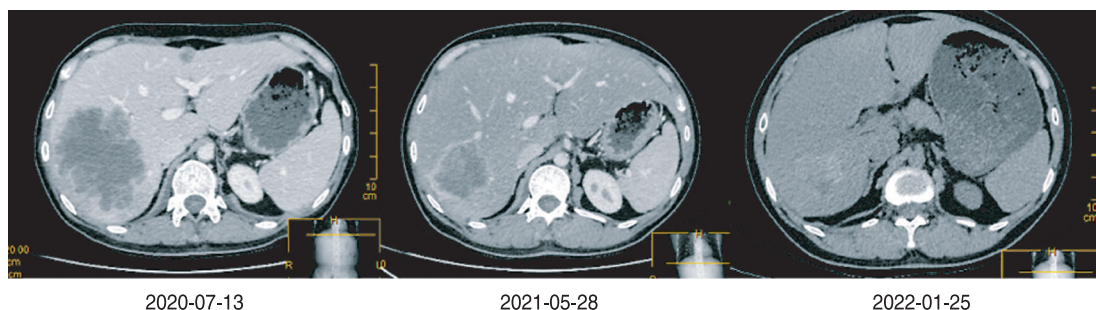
CT revealed tumor masses at different times of the disease
